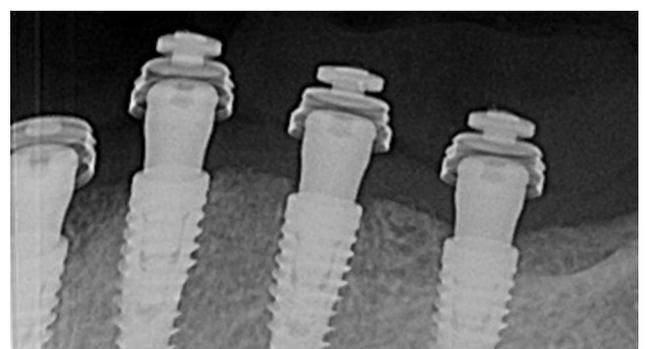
X-ray of implants after fixation of the retentions in the lower jaw.
